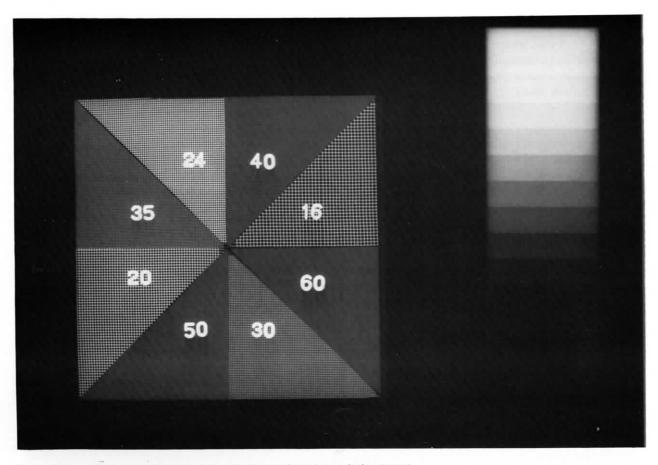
Original radiograph of step wedge and mesh resolution target.
